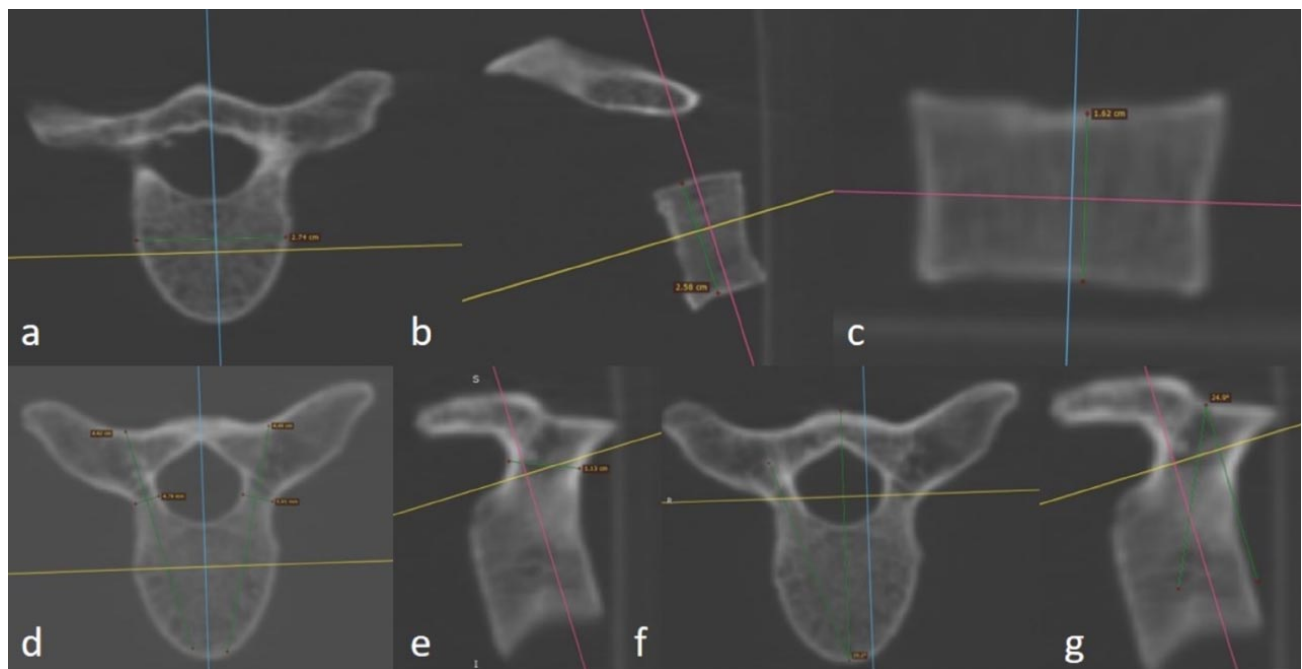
Representative example demonstrating how (a) vertebral body width, (b) length, and (c) height; (d) pedicle width, (d) length, and (e) height; as well as (f) pedicle transverse angle (PTA) and (g) pedicle sagittal angle (PSA) were measured on multiplanar reformatted (MPR) CT images.
